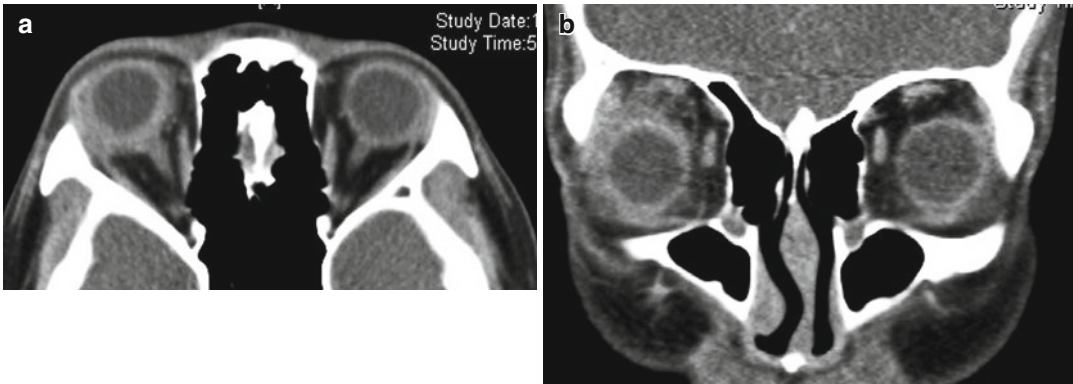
(a) Axial CT showing lacrimal gland enlargement with adjacent orbital inflammation. (b) Coronal CT showing lacrimal gland enlargement with adjacent tissue involvement
